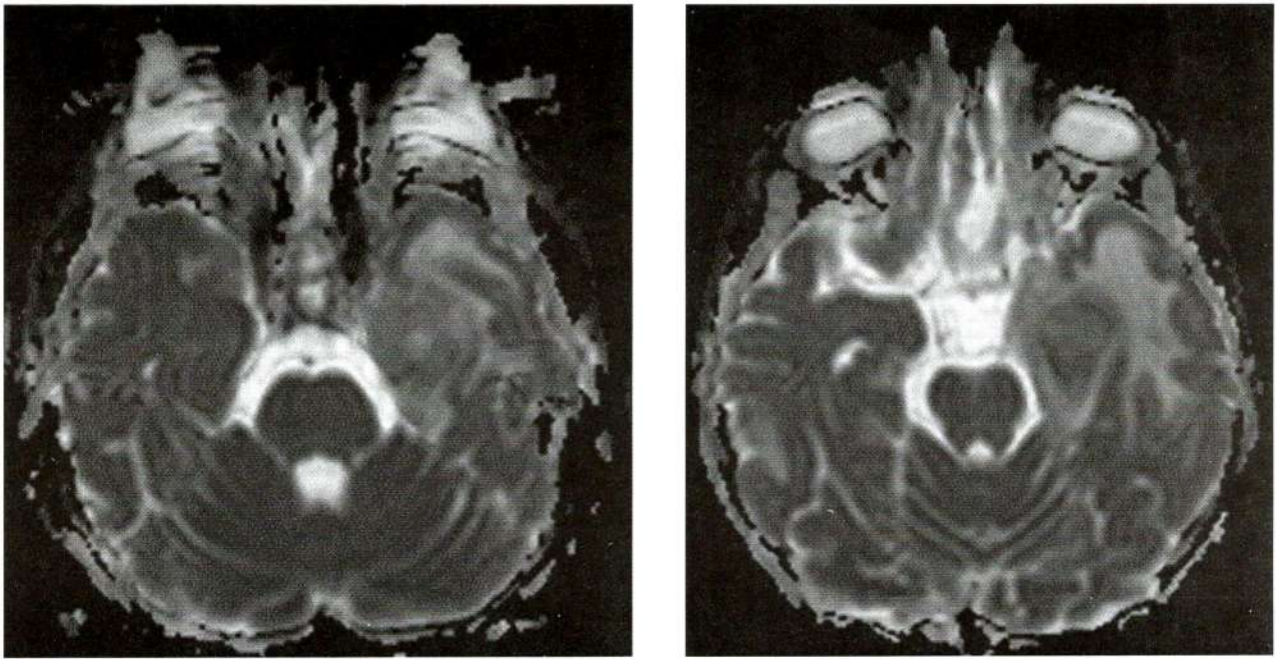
ADC mapping from DWI showed partial restricted diffusion at posterior wall and partly left anterolateral wall as well as some area in central portion.
